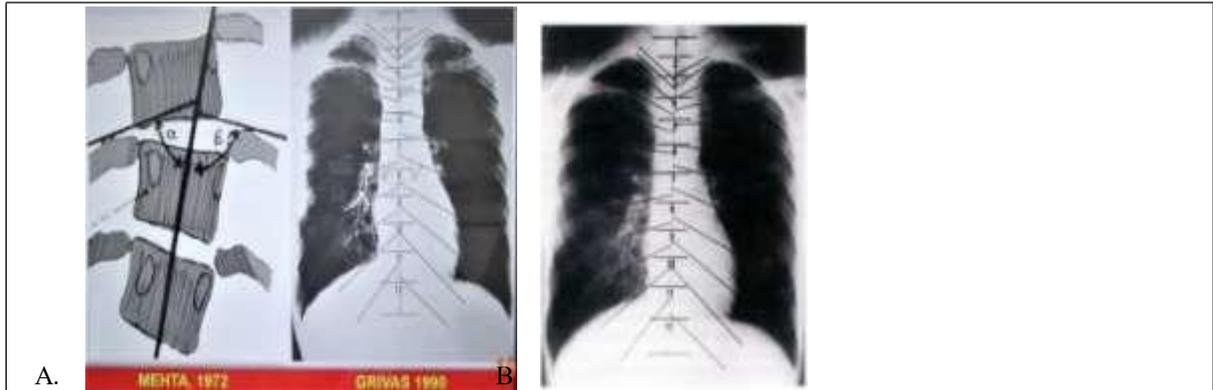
Chest radiograph showing the methods of measurement of RVAs, A [59], B [modified from Grivas et al 2002, [64)].
